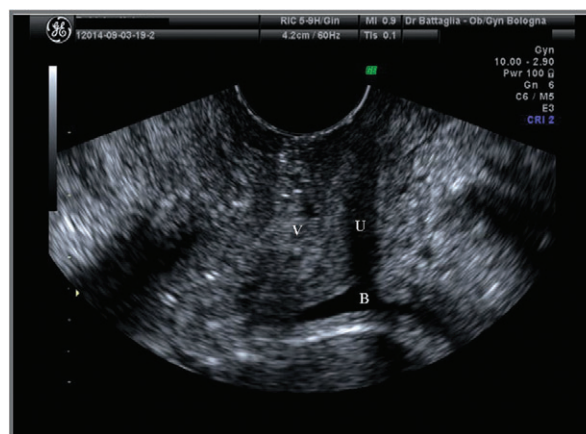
Transvaginal ultrasonography: sagittal view of the normal urethra and bladder neck. B = Bladder; U = Urethra; V = Vagina.
